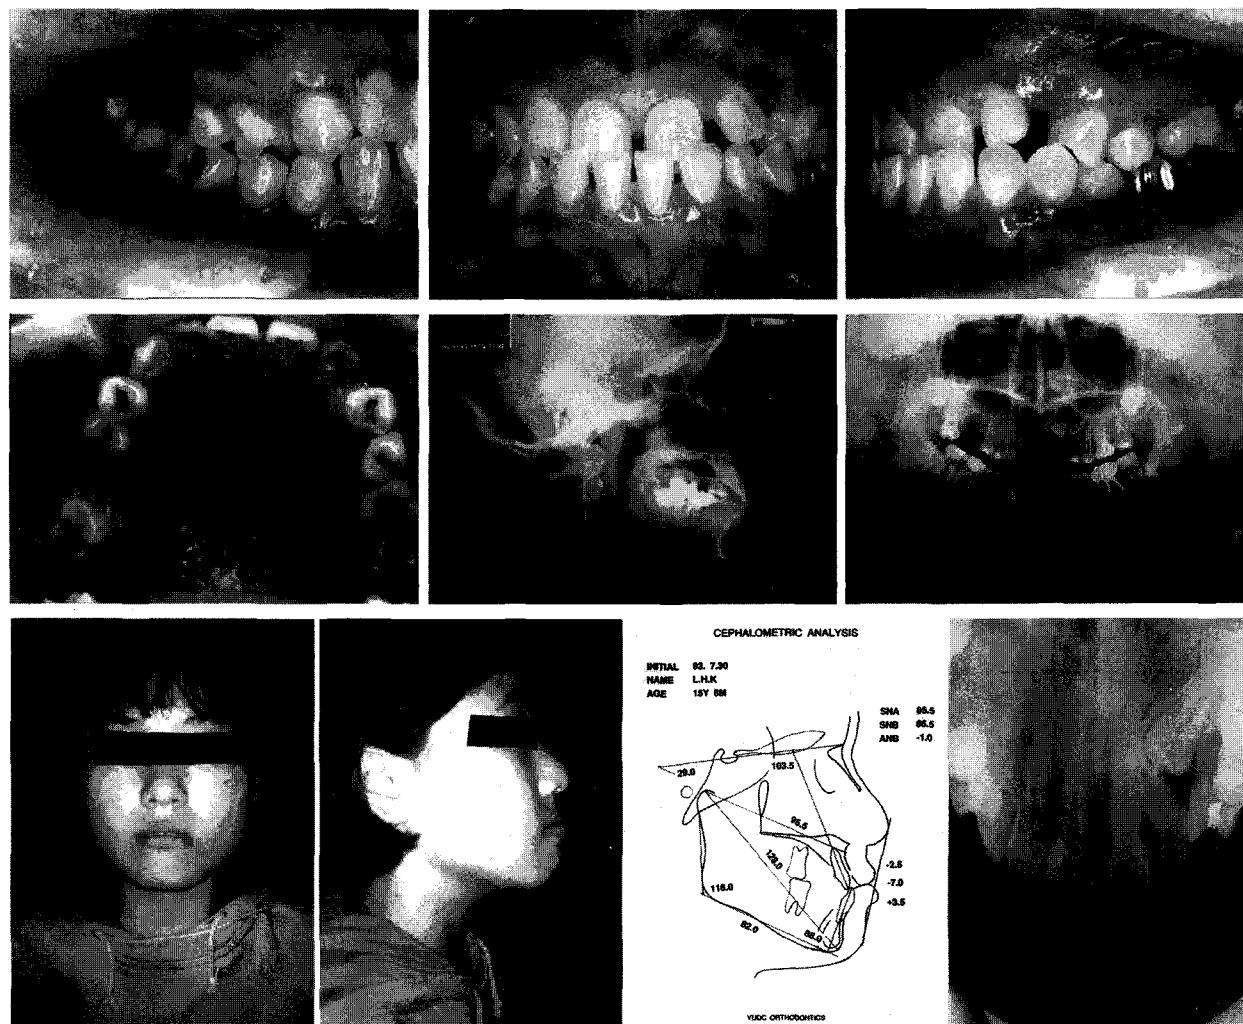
Case 2. Initial intraoral photos, facial photos, lateral cephalogram, orthopantomogram, occlusal view, and cephalometric tracing
